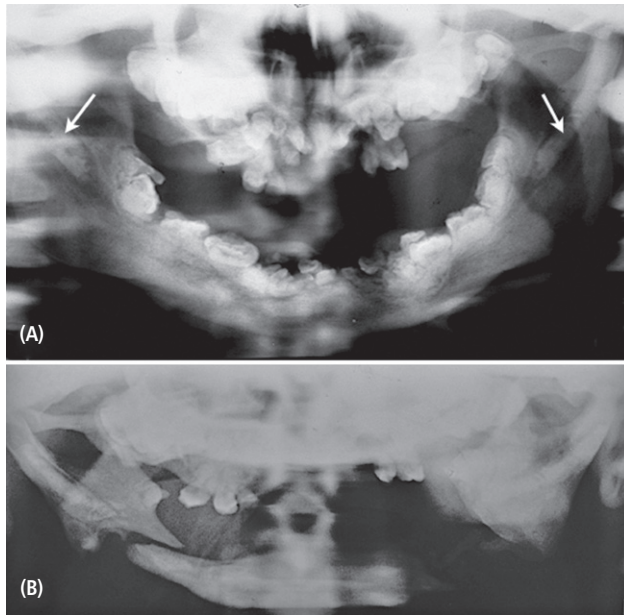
Panoramic radiographs of patient taken at age 15 (A) and 25 (B) years. Note the abnormal tooth shapes and severe root malformation. Molar roots are rudimentary, and there is crowding of unerupted teeth. The arrows indicate calcified stylohyoid ligaments. Note also the narrow body of the mandible and the fracture of mandible on the right side (B).
